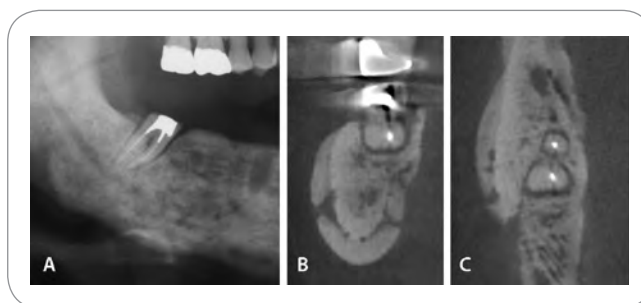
Bisphosphonate-related osteonecrosis of the jaws. B and C were acquired using J. Morita CBCT machine. Images were reformatted in One Data Viewer. (A) Section of a panoramic radiograph showing sclerotic mandibular bone with discrete radiolucencies. (B) Coronal section thorough mandibular second molar. Note prominent periosteal new bone formation around the body of the mandible with localized disruption. The bone is sclerosed with indistinguishable trabecular pattern. (C) Axial section of the mandible. Note prominent dense periosteal bone formation on the buccal aspect.
